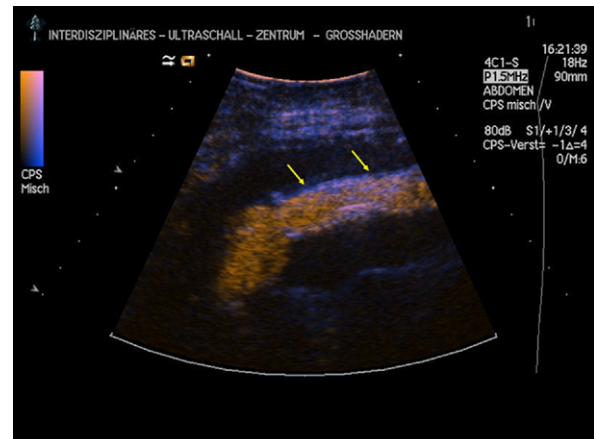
Intraoperative contrast-enhanced ultrasonography demonstrating the right iliac stent graft (yellow arrows) extension without a detectable endoleak.
